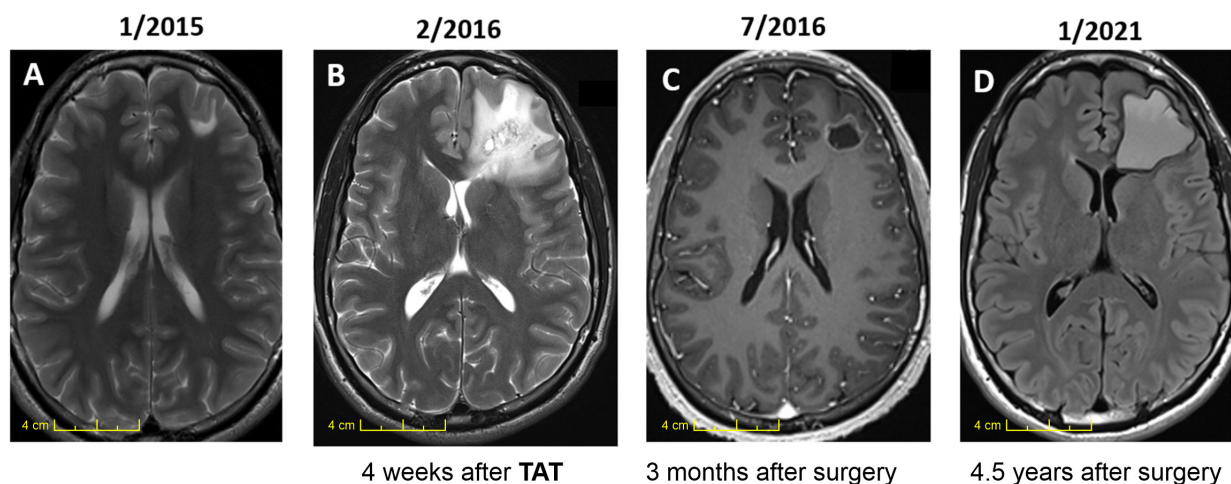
TAT demarcates the true initial tumor volume. In this 24 year old male patient, a small left frontal lesion was detected using MRI, following a focal seizure (image (A)). The biopsy disclosed a diffuse invasive grade 2 astrocytoma. Thus, 2 GBq ^{213}Bi]Bi-DOTA-substance P was locally injected into the extracellular tumor matrix via a port-catheter system, inducing a strong perifocal edema reaction (image (B)). Two months later, the radionecrotic lesion was resected, creating a resected cavity of about 5 mL (image (C)). Over the next 4 years, the gradual resorption of the tumor margins manifested in a volume of about 50 mL (image (D)), at which point, it came to a halt. The true initial tumor volume is likely to have been 50 mL and not 2 mL, as shown on the initial MRI (image (A)). No neurological deficits ensued; KPS was 100.
